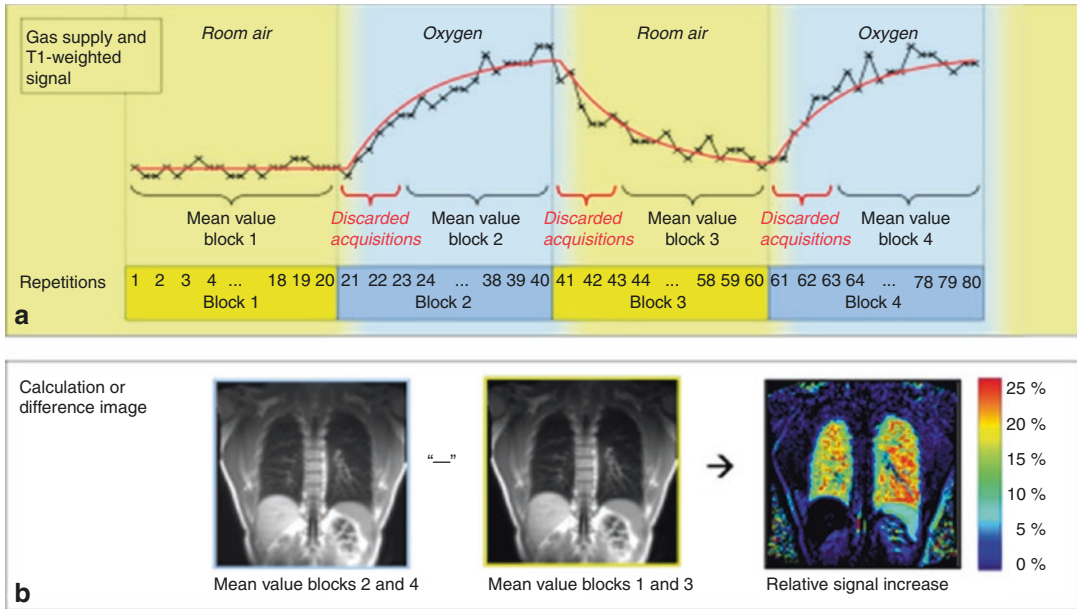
(a, b) Block paradigm for oxygen-enhanced lung MRI. (a) Data acquisition: T_1 -weighted images are continuously acquired in four blocks with 4×20 repetitions; in blocks 1 and 3, room air is supplied; in blocks 2 and 4, pure oxygen. The T_1 -weighted signal varies relatively slowly after switching the gas supply and reaches exponentially its new steady state. Thus, several repetitions should be discarded before calculating the pixel-by-pixel
